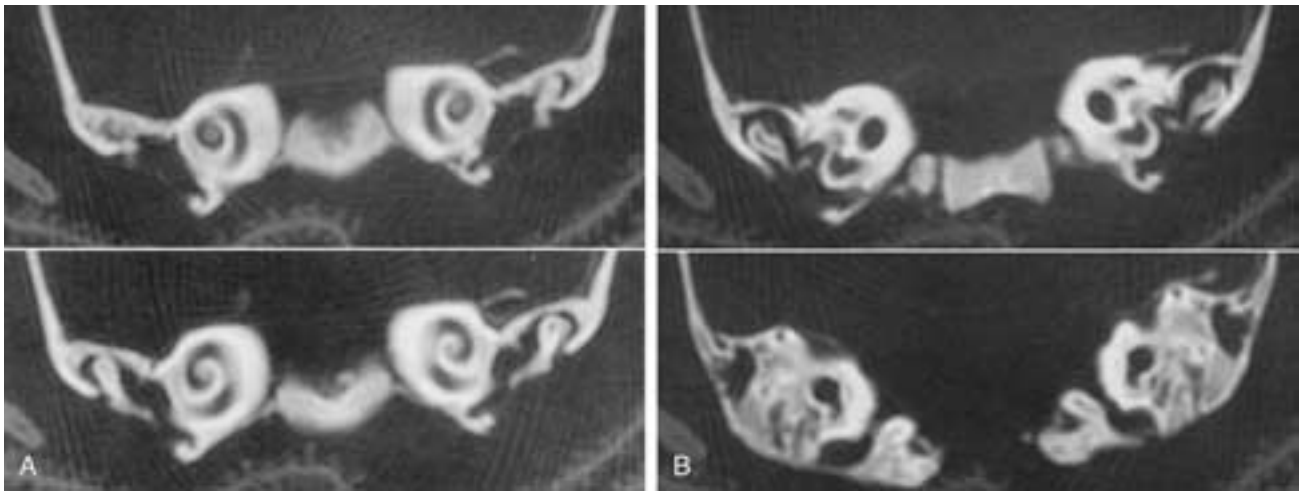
Coronal CT scan, late fetal stage. A, The position of the temporal bone in the inferolateral part of the skull is identified. Although the malleus and cochlea are well formed, there is no bony external auditory canal. The tympanic membrane faces inferolaterally the undersurface of the skull. B, The ossicular chain is well formed and has achieved its adult size and shape. No significant mastoid process is identified. (Courtesy of the Louis E. Etter Collection.)
